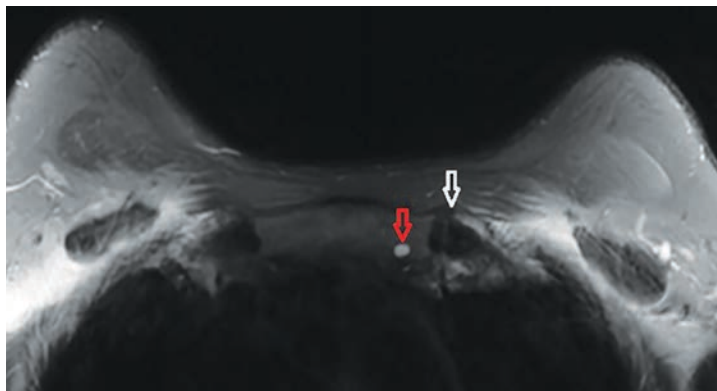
Axial T2 fat-suppressed MR image at the level of the sternoclavicular joints. There is a T2 hyperintense, well-circumscribed lesion adjacent to the left sternoclavicular joint (red arrow). This lesion was T1 hypointense and did not enhance, consistent with a cyst. Mild periarticular spurring is also seen at the left sternoclavicular joint (white arrow). Findings are consistent with osteoarthritis with subchondral cystic change.
